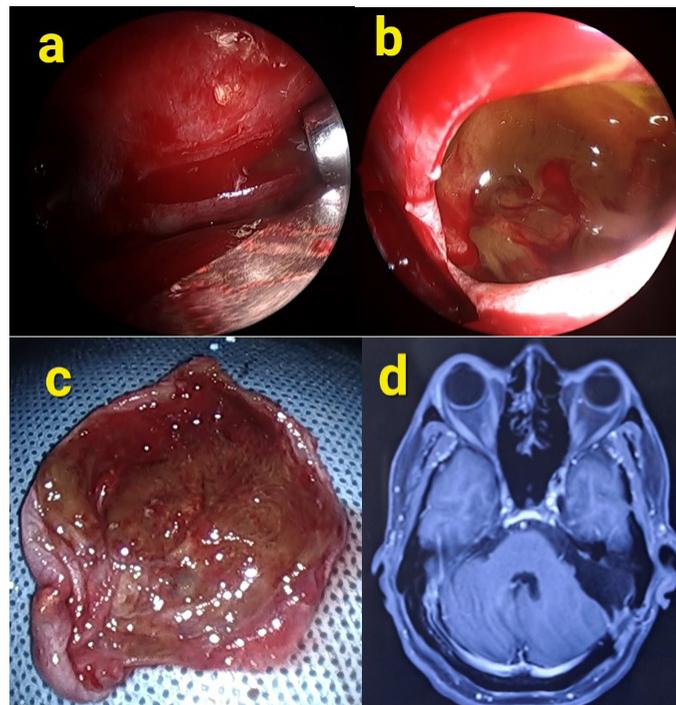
Operative findings and postoperative MRI scan of petrous neurenteric cyst
